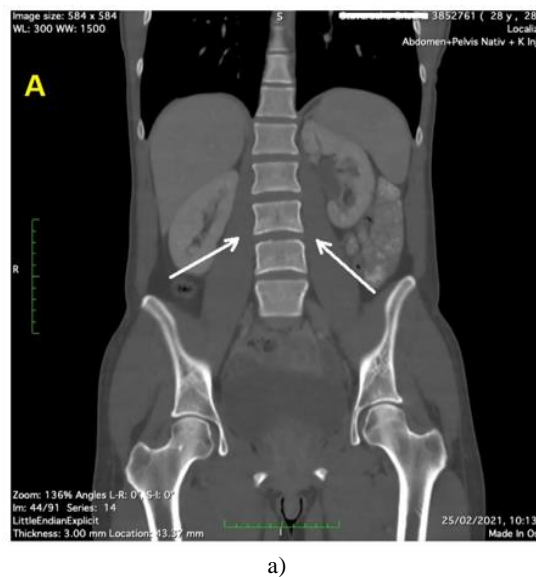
CT examination at the level of third lumbar vertebra L3 reconstructed in the coronal plane (image a) and axial plane (image b) highlighting the sarcopenia of the psoas muscles as well as the muscles of the abdominal walls (internal oblique, external oblique, latissimus Dorsi).
